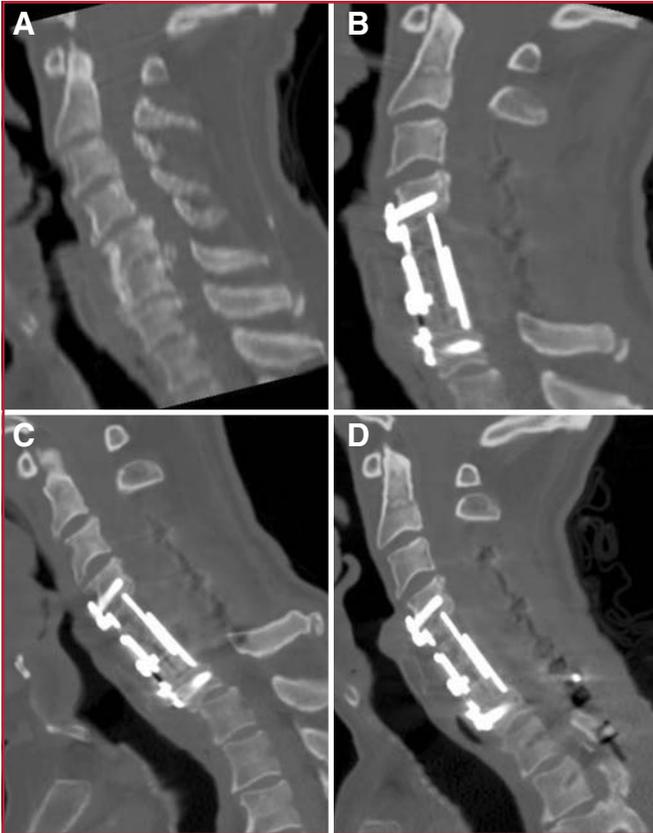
A*, sagittal computed tomographic reconstruction of a 73-year-old male with spondylotic myelopathy based on stenosis at C4 to C7 with anterior and posterior compression. *B*, corpectomy at C5 to C6 with TPS implantation and posterior decompression at C3 to C6 with lateral mass screw fixation at C3 to C6 were performed. *C*, 1 year postoperatively, anterolisthesis with kyphosis at the cervicothoracic junction was demonstrated. *D*, posterior revision surgery with additional pedicle screw fixation and extension of the construct to T2 were performed.
